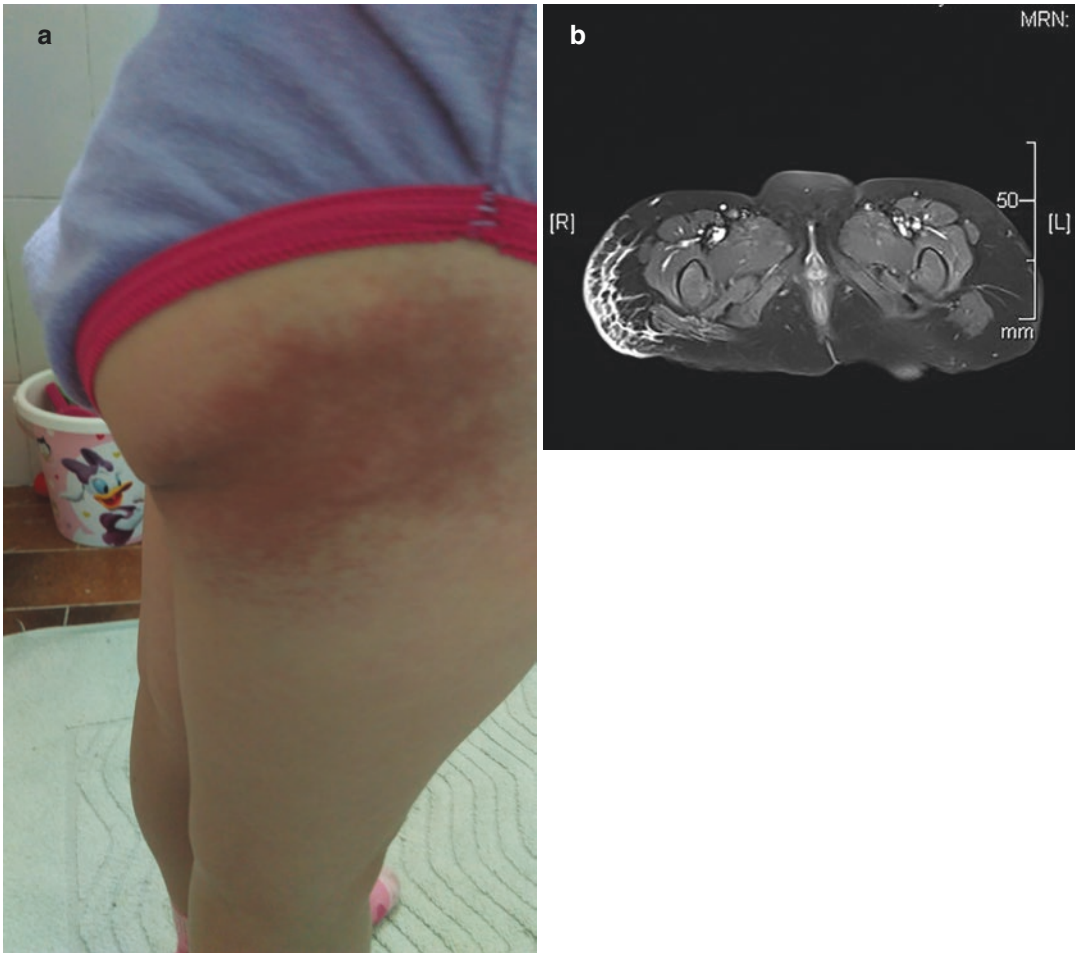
Tufted angioma with KMP in a 3-year-old girl. (a) Superficial firm and purpuric lesion at the right gluteal region. (b) Infiltrative growth with contrast enhancement in the subcutaneous region confirmed by MRI
